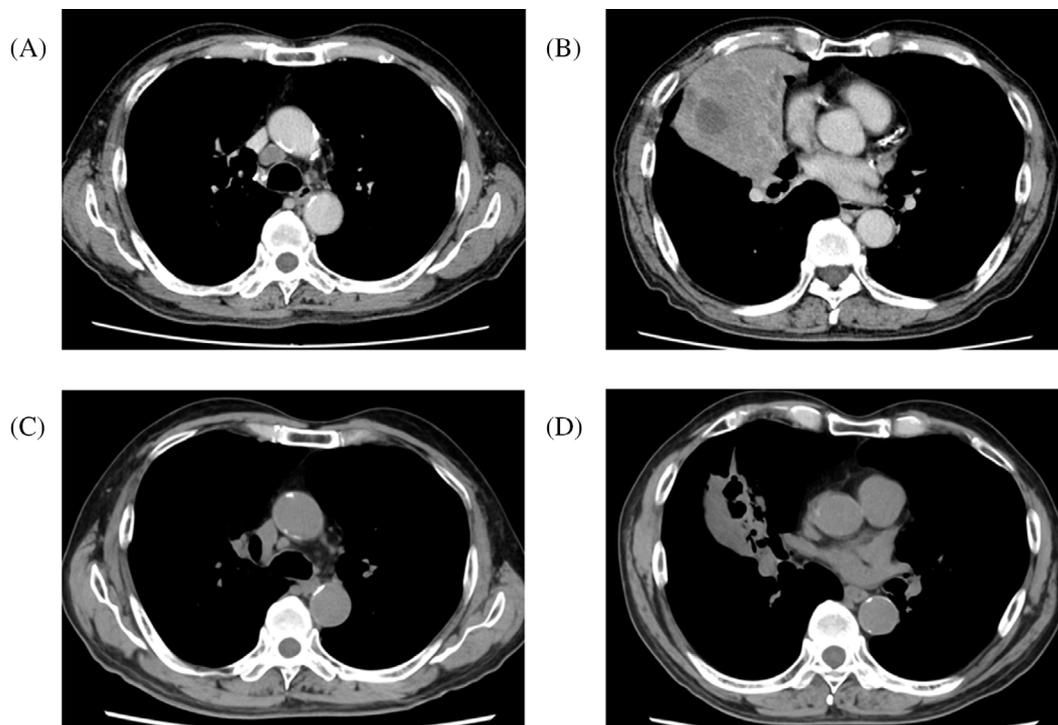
Chest computed tomography images with contrast enhancement of the primary tumour in the right middle lobe (B) and mediastinal lymph node metastasis to #4R (A) are shown. Both lesions appear reduced in size after two cycles of chemoimmunotherapy (C, mediastinal lymph node; D, primary tumour)
